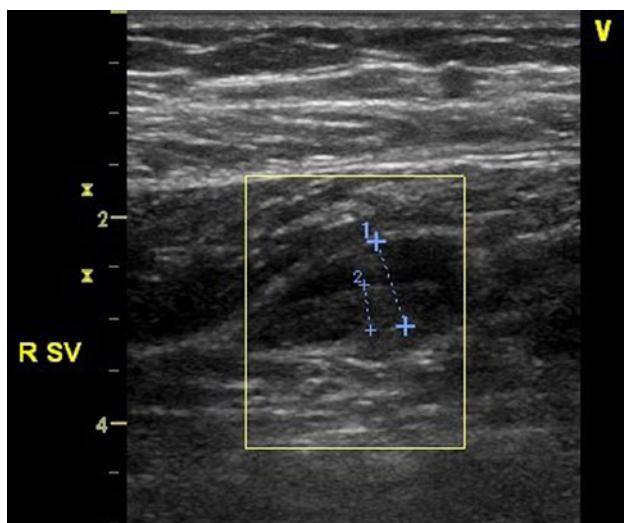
B-mode ultrasonogram of the right soleal vein on the second postoperative day; thrombus formation can be seen
